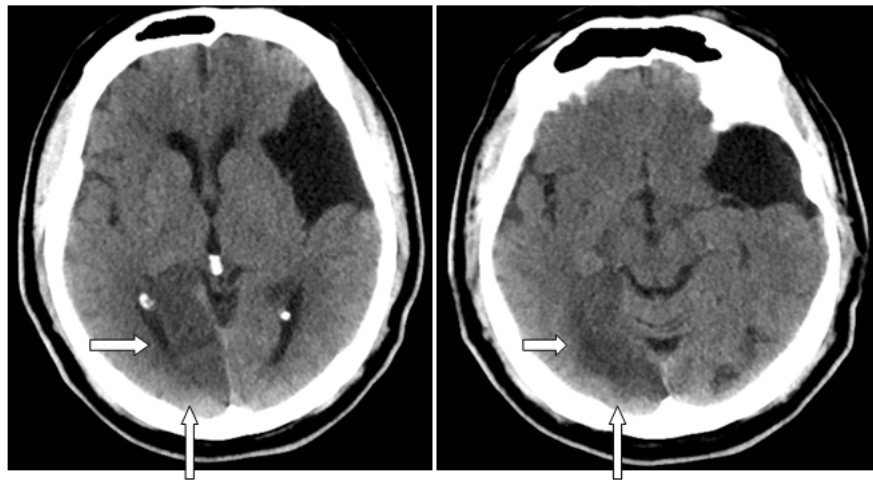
The CT images obtained at the 24th hour encountered a hypodense edemateous field suggestive of infarct in the location compatible with the PCA irrigation area of the right occipital lobe (arrows)
